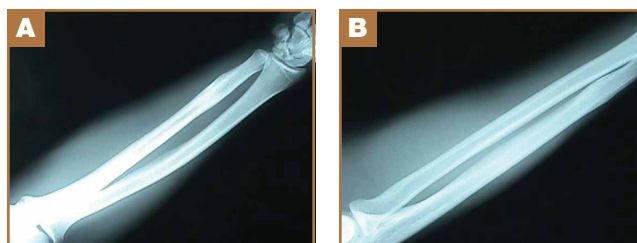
(A) Anteroposterior view and (B) lateral view of 1-year follow-up radiographs, showing complete fracture healing and remodeling.
